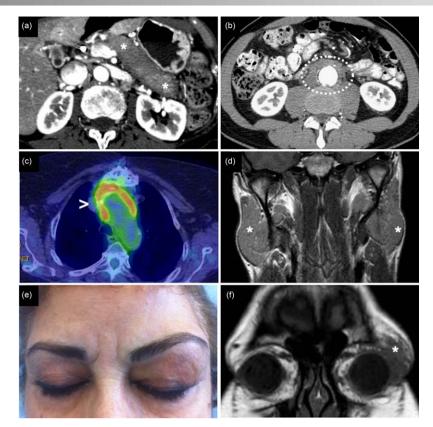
Clinical and radiological presentation of IgG4-related disease (IgG4-RD). (a) IgG4-related autoimmune pancreatitis: computed tomography scan showing a 'sausage-like'-shaped pancreas with a surrounding rim of hypodense tissue (asterisks). (b) Retroperitoneal fibrosis with periaortic involvement (circle). (c) Inflammatory aneurism of the thoracic aorta showing <sup>18</sup>fluorodeoxyglucose uptake on positron emission tomography (arrowhead). (d) Magnetic resonance showing bilateral parotid enlargement due to IgG4-RD (asterisks). (e,f) Clinical and radiological appearance of IgG4-related orbital pseudotumour (asterisk).
